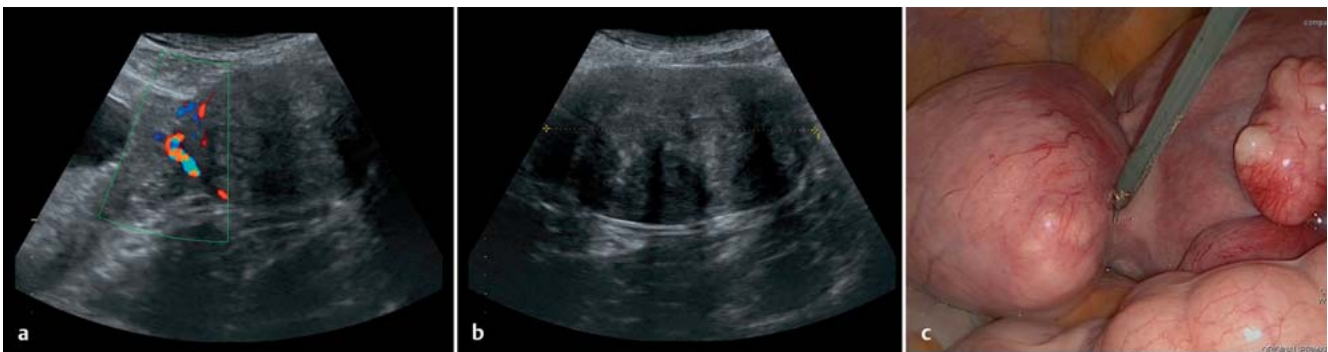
a to c Case 7 (see [Table 2](#)): a ultrasound view of source of blood flow to the leiomyoma; b ultrasound view of the uterine mass; c laparoscopic exposure of the leiomyoma stalk.
